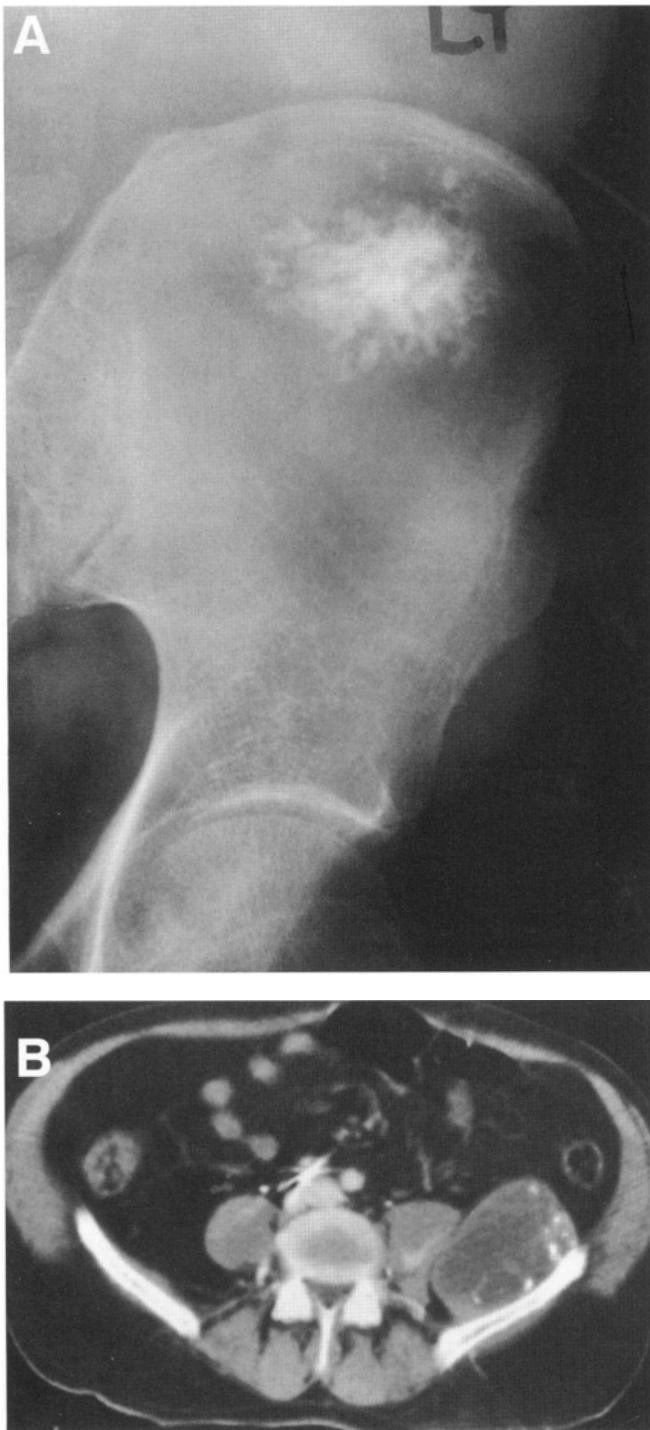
A 44-year-old patient presented with left flank pain. (A) Plain radiographs revealed a cartilage-forming lesion in the left ilium. On the basis of that study alone it seemed that this was an intraosseous lesion. (B) CT showed an extensive tumor on the medial aspect of the ilium with destruction of the inner table and extension to the pelvis. CT-guided core needle biopsy showed intermediate- to high-grade chondrosarcoma and the patient underwent en-bloc resection of the ilium with the large extraosseous component. (Cancer: Principles and Practice of Oncology, 5th Edition, 1997 38.3:1789–1852)
